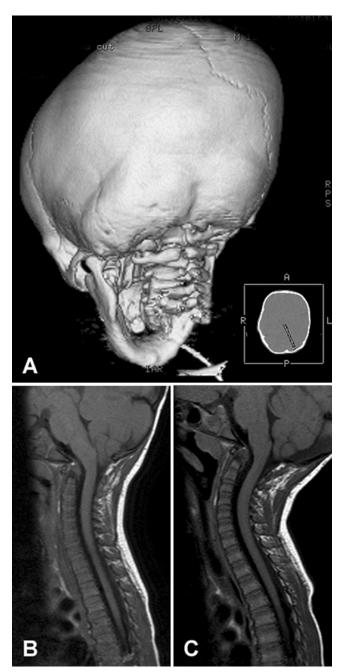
Imaging studies obtained in a 9-month-old boy presenting for evaluation of an abnormal head shape. A: Reconstructed CT scan demonstrating synostosis of the left lambdoid suture. Inset: Two-dimensional depiction of the "viewing angle" that is depicted in the larger 3D image. B: Sagittal MR image showing cerebellar tonsillar descent to 5 mm below the foramen magnum. A posterior CVR with suboccipital craniectomy for CM decompression was performed. The dura was not opened. C: Two-year postoperative MR image revealing improvement in the degree of tonsillar descent and crowding at foramen magnum.
